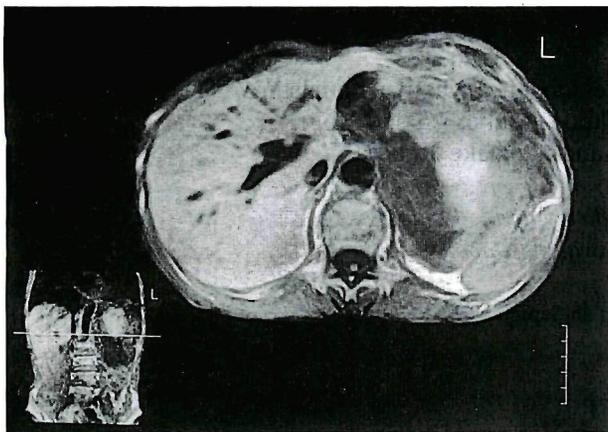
MRI (T1) demonstrating a huge mass within high intensity suggesting bleeding and cystic patterns in the upper left quadrant of the abdomen.
